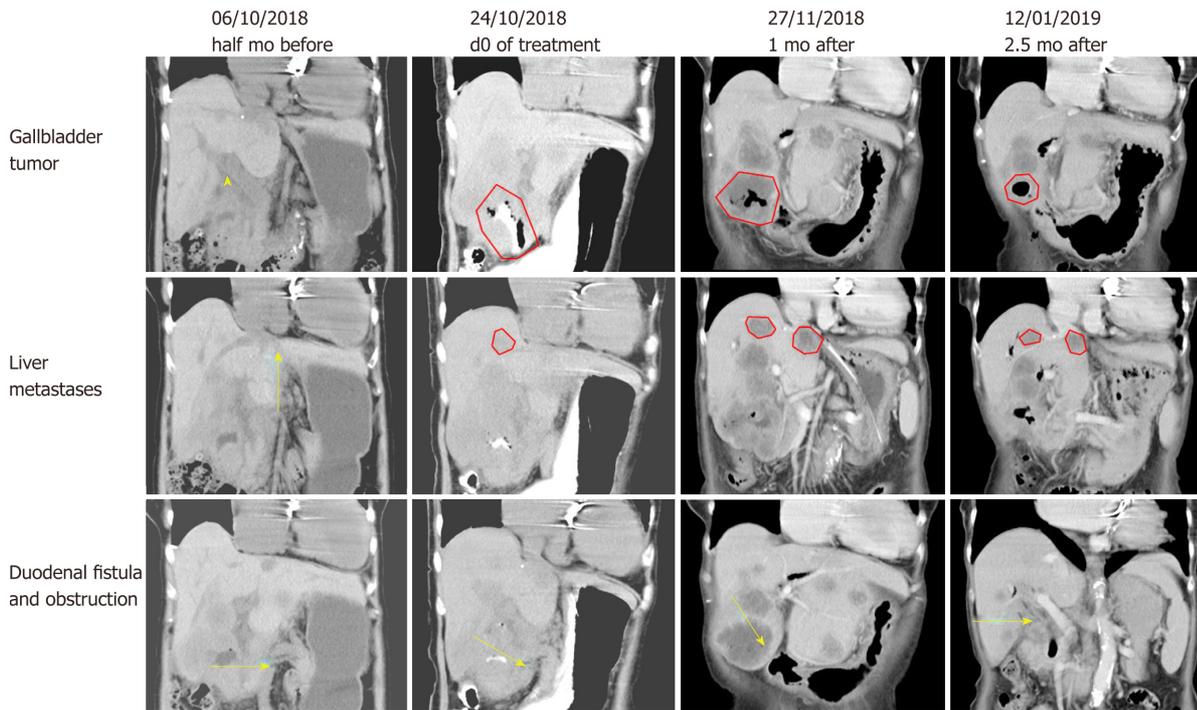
Computed tomography imaging findings at different time points before and after hydrogen treatment. In the first line of figures, the triangle and the contour lines represent the location and range of the gallbladder. In the second line of figures, the contour lines represent the location and range of liver metastases. In the third line of figures, the arrows represent the location of the duodenal fistula or obstruction.
